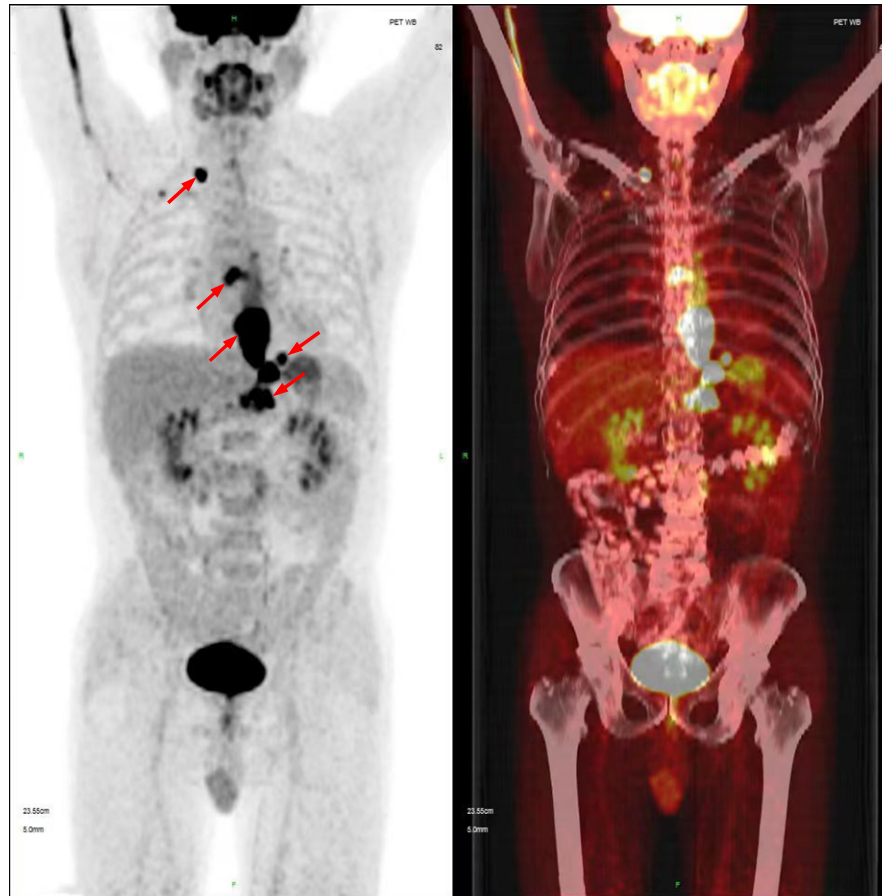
The ^{18}F FDG PET-CT scans showed the baseline disease status, indicating multiple lymph node metastases (1R/7/16/17/18/19/20) with enlarged and fused lymph nodes. Red arrows indicate the locations of tumor distribution. The patient was staged as cT4N3M0. After multidisciplinary discussion, it was concluded that there were no indications for radical surgery or definitive chemoradiotherapy.
